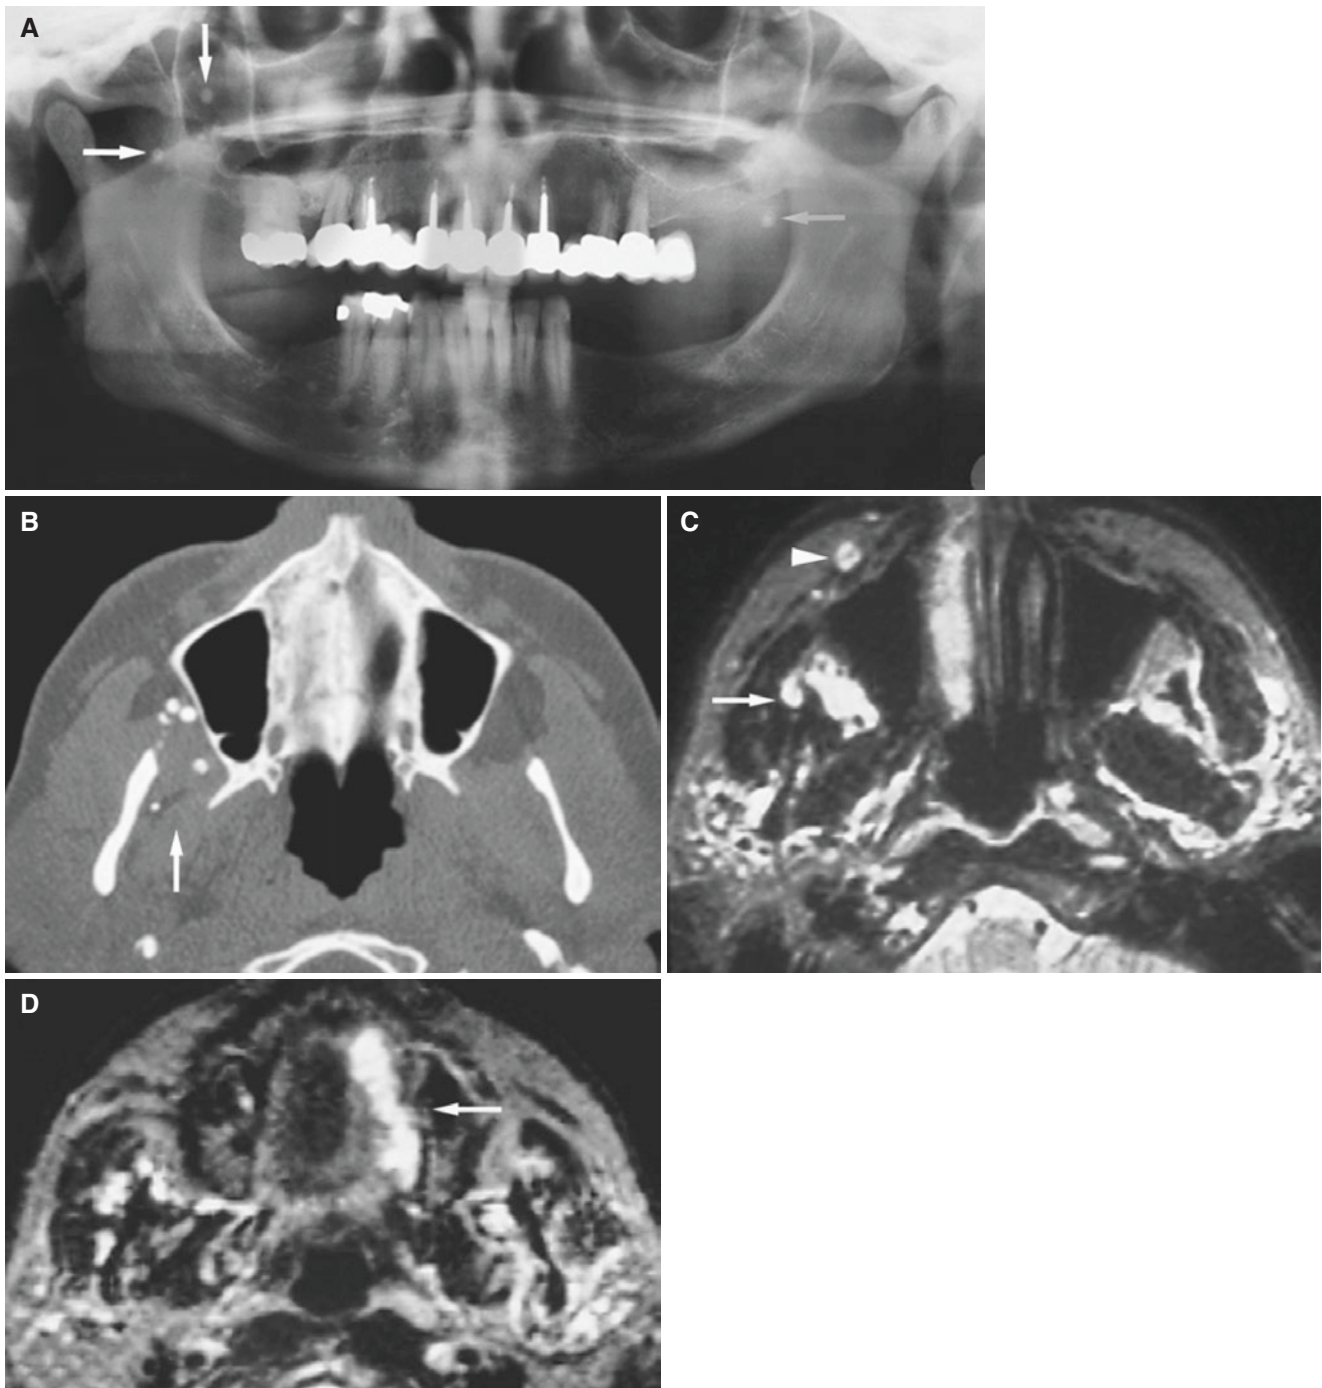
Venous malformations of the cheek and hard palate; 44-year-old female with painless swelling in the hard palate that was believed to be a dental abscess, but on incision did not show any pus collection. (A) Panoramic view shows tiny calcifications (*arrows*). (B) Axial CT image shows multiple small, dense calcifications (*arrow*).
